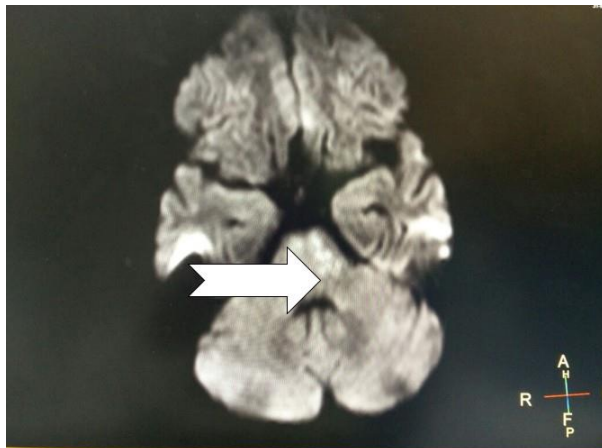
MRI brain showing patchy areas of hyperintensities in pons suggestive of demyelination
